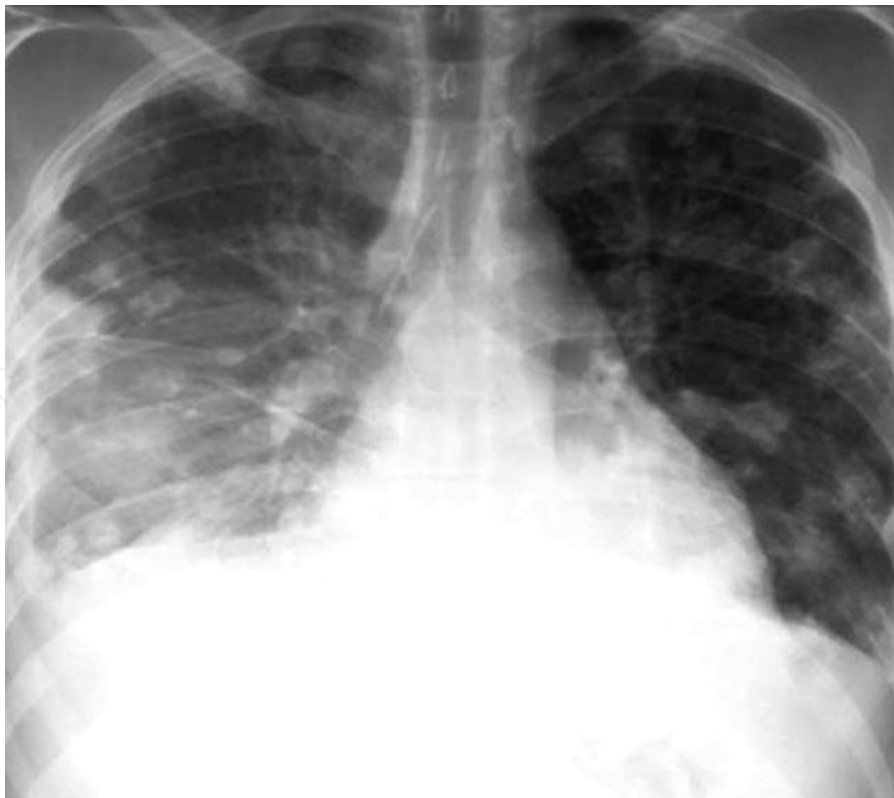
Chest X-ray showing bilateral opacities. Also it can be observed the presence of pleural fluid
